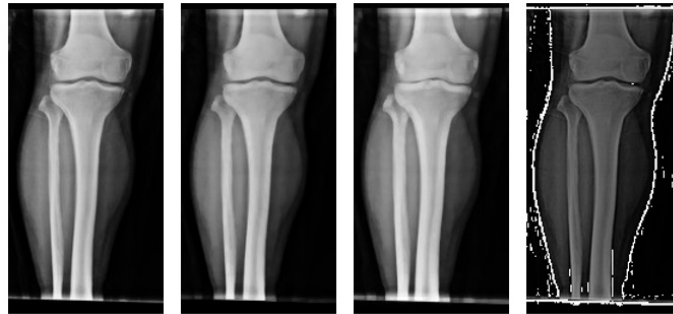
X-ray images of a person without osteoporosis, from left to right: unfiltered, with aperture filter, with dilatation filter, and with a high-pass filter.
